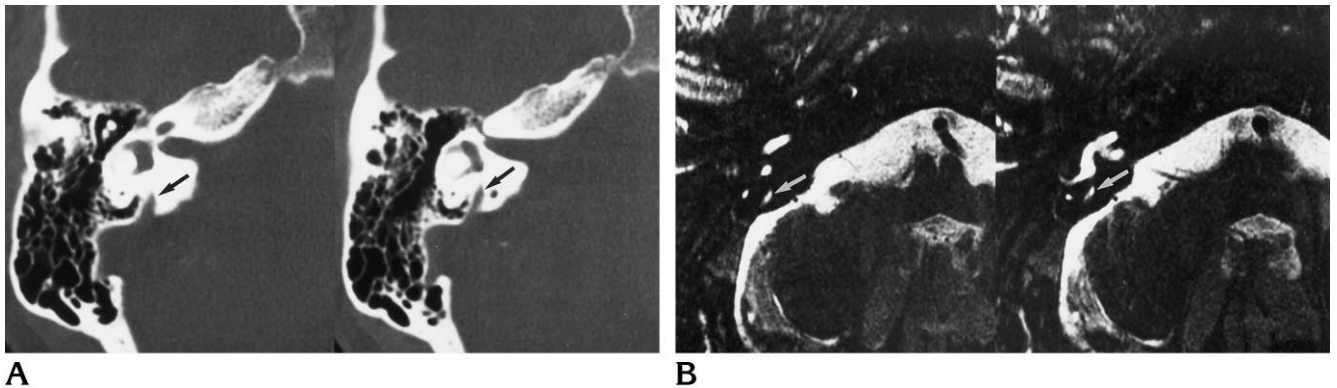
Enlarged bony vestibular aqueduct on temporal bone CT with normal findings at MR imaging.
